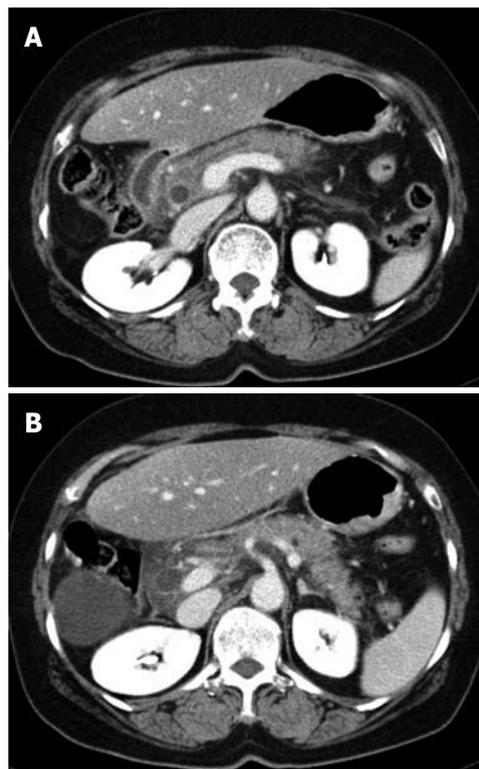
Abdominal computed tomography scans showed diffuse swelling and infiltration in head, body (A) and tail (B) of pancreas without obvious stone, indicating acute pancreatitis.
